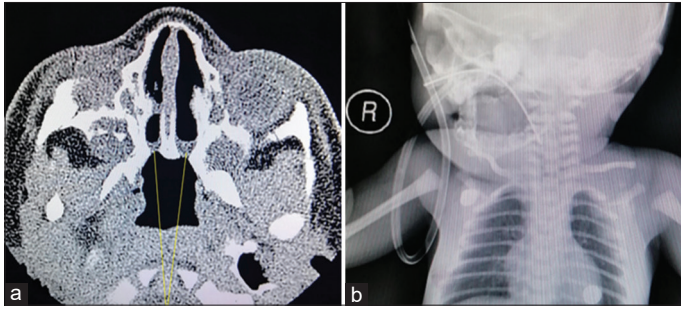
(a) High-resolution computed tomography with contrast revealed bilateral membranous type choanal atresia; (b) Follow-up X-ray showed successful placement of bilateral stent *in situ*
